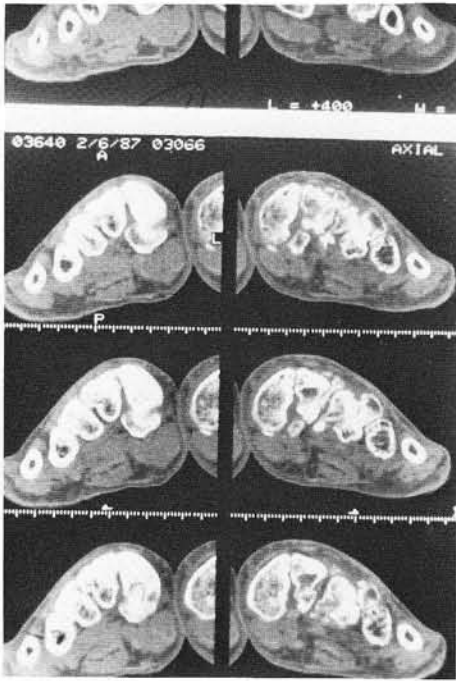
CT scan showing severe destruction at LisFranc's joint one year following injury.
